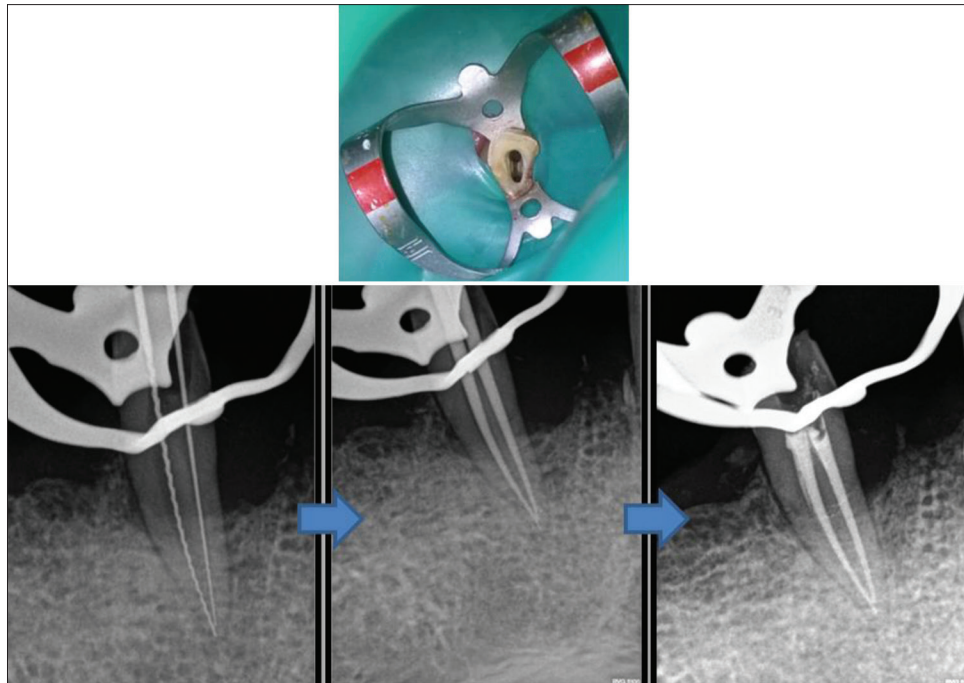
Access opening, working length, master cone, and obturation radiograph
